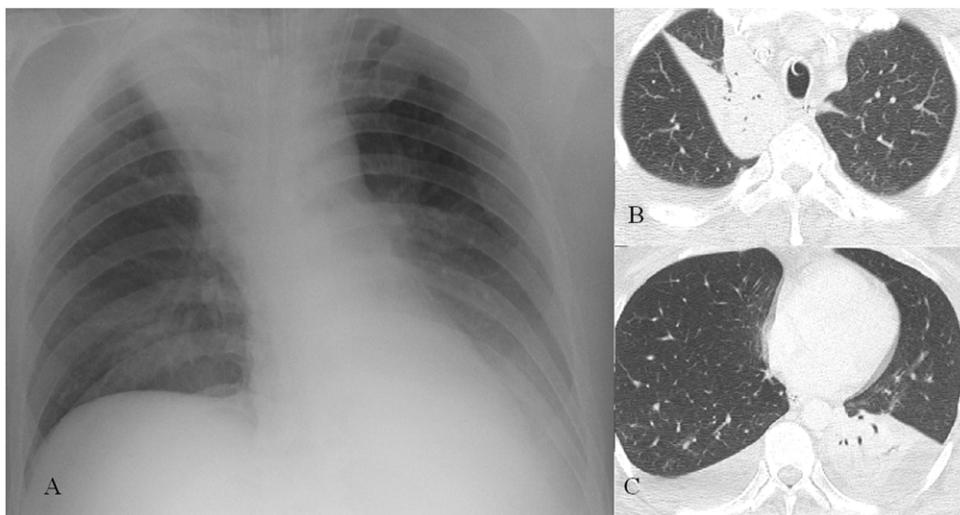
Chest radiography and computed tomography at fourth post-injury day. Panel A: Chest radiography clearly depicts the electric arc. Panel B: right lung showing upper lobe damage. Panel C: left lung showing lower lobe damage.
